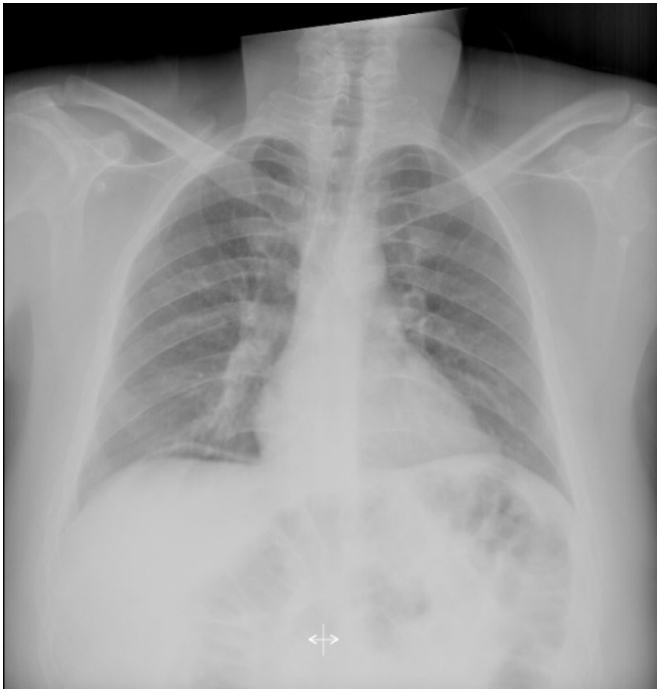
Abdominal X-ray showing subdiaphragmatic free air.
